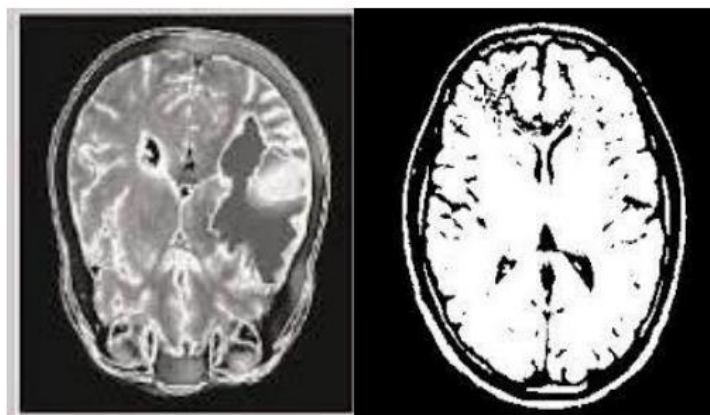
Difference between MRI scan image and grayscale image.
